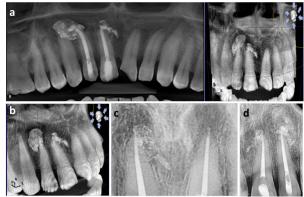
(a) Post-obturation panoramic view, (b) CBCT showing the volumetric view, (c) Post-RCT one-year follow-up shows appreciable healing, (d) Post 2 years follow-up radiograph shows the healing progress.
